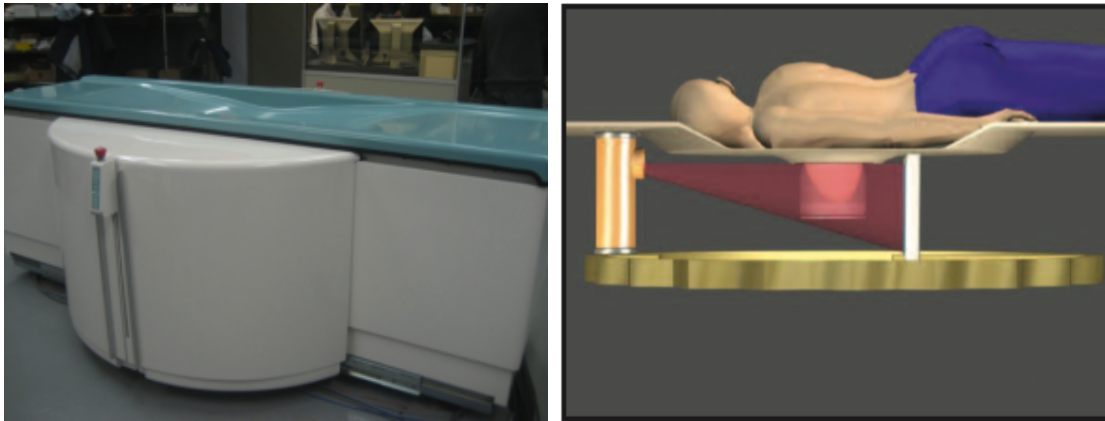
Koning breast CT system (model CBCT 1000) (on the left), principle of the system (on the right).
